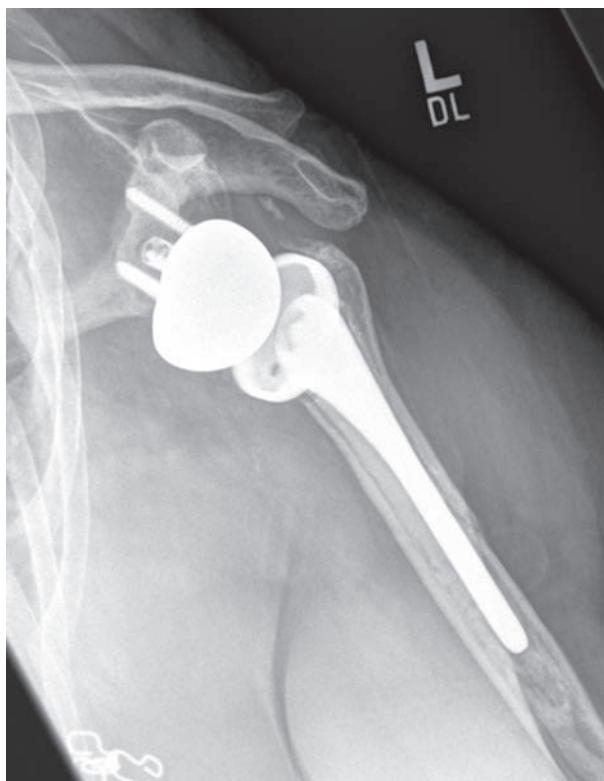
Stem loosening (radiographically loose). Radiolucent lines identified at 24 months. All radiographs contain lucency lines except in zones 2 and 4.
